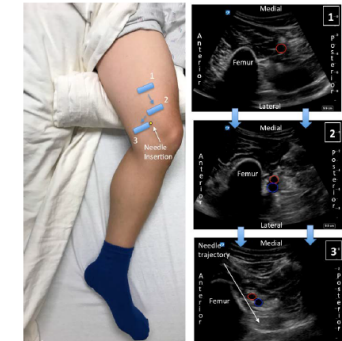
Scanning sequence for iPACK using the posteromedial acoustic window with corresponding sonograms. Red circle = popliteal artery; blue circle = popliteal vein.
